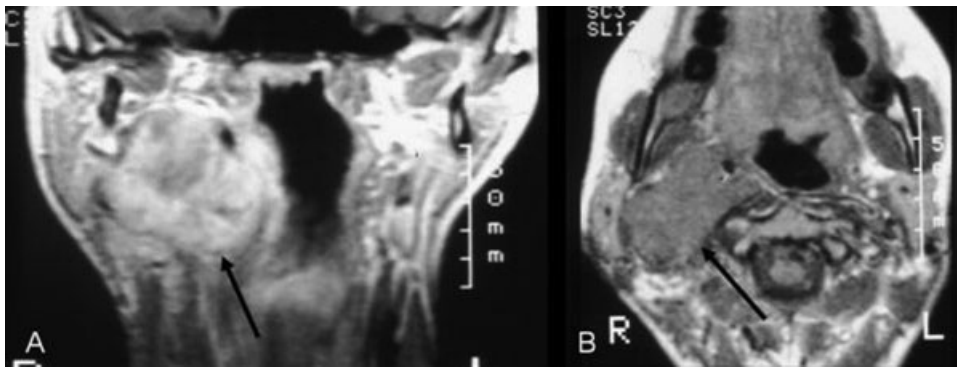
Preoperative T1-weighted coronal (A) and axial (B) MR images showing a tumor formation within the right upper parapharyngeal space invading the jugular foramen.
